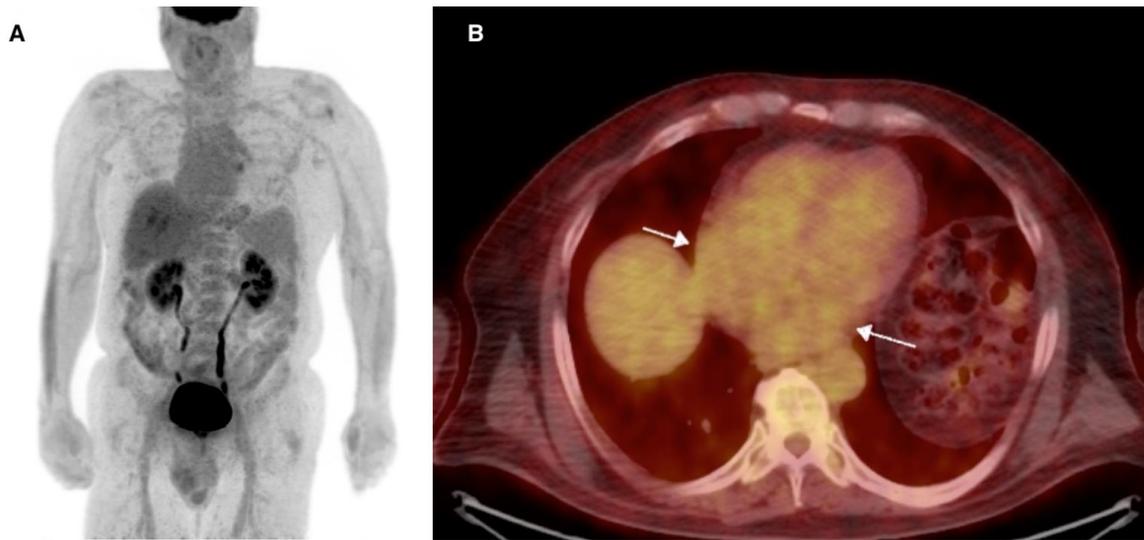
(A) MIP (Maximum Intensity Projection) image of whole-body ¹⁸F-FDG PET/CT pre-therapy staging scan in a patient with colorectal cancer, acquired 62 minutes after IV injection of 9.8 mCi of ¹⁸F-FDG. (B) Trans-axial fused ¹⁸F-FDG PET/CT image demonstrating diffuse blood-pool FDG activity in the myocardium (white arrows) SUV_{max} 3.3 and SUV_{min} 1.8.
